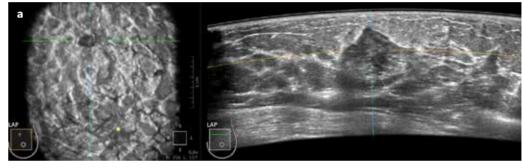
b. Automated breast ultrasound (ABUS) of the left breast, medial compression, continuation of the series shown on Fig. 2.a. Images 6-11/23: there are two tissue defects in the upper half of the breast; the larger, more superficial, increases in size on images closer to the chest wall (6-11/23), while the smaller tissue defect is seen only on slices 7-9/23.
